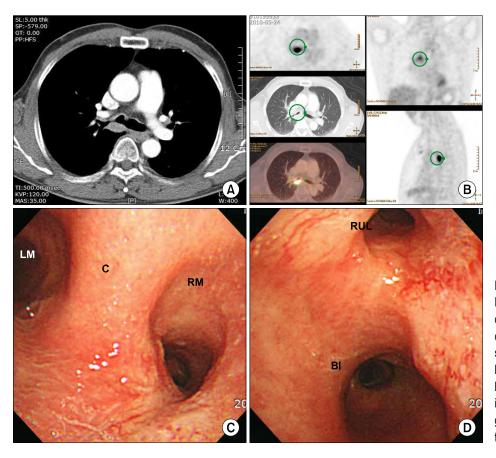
Preoperative chest CT and PET-CT show about 2.5 cm mass on right main bronchus involving carina (A, B). Preoperative bronchoscopic findings show endobronchial lesion on the orifice of right upper lobe involving carina (C, D). C=Carina; LM=Left main bronchus; RM=Right main bronchus; BI=Bronchus intermedius; RUL=Right upper lobe.
